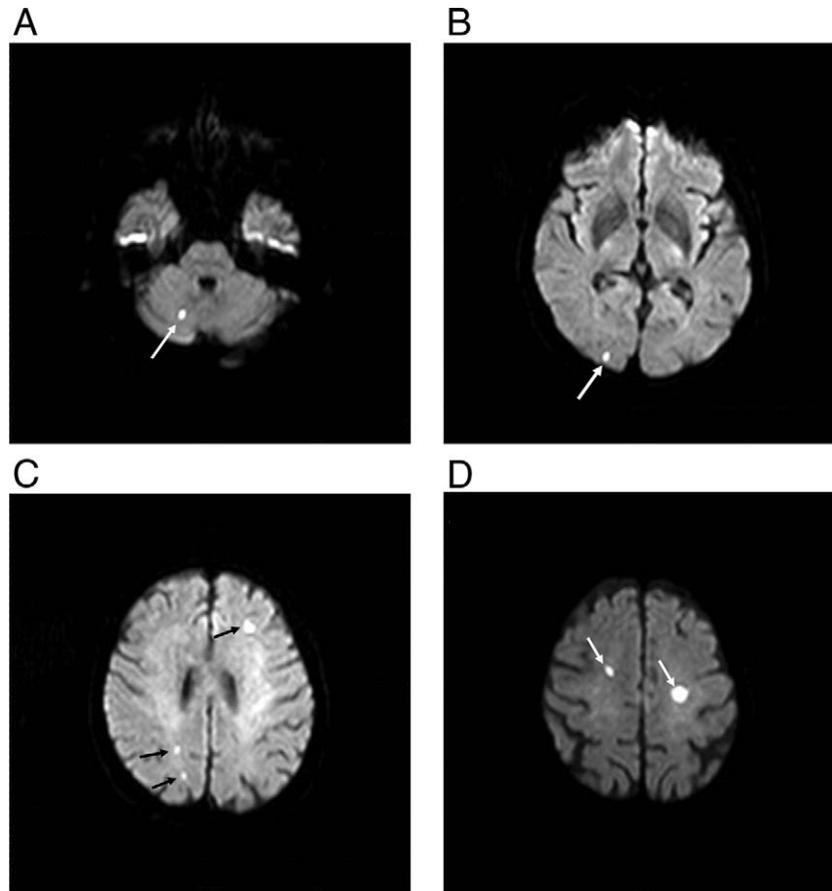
DW-MRI Images Following TF-TAVI
